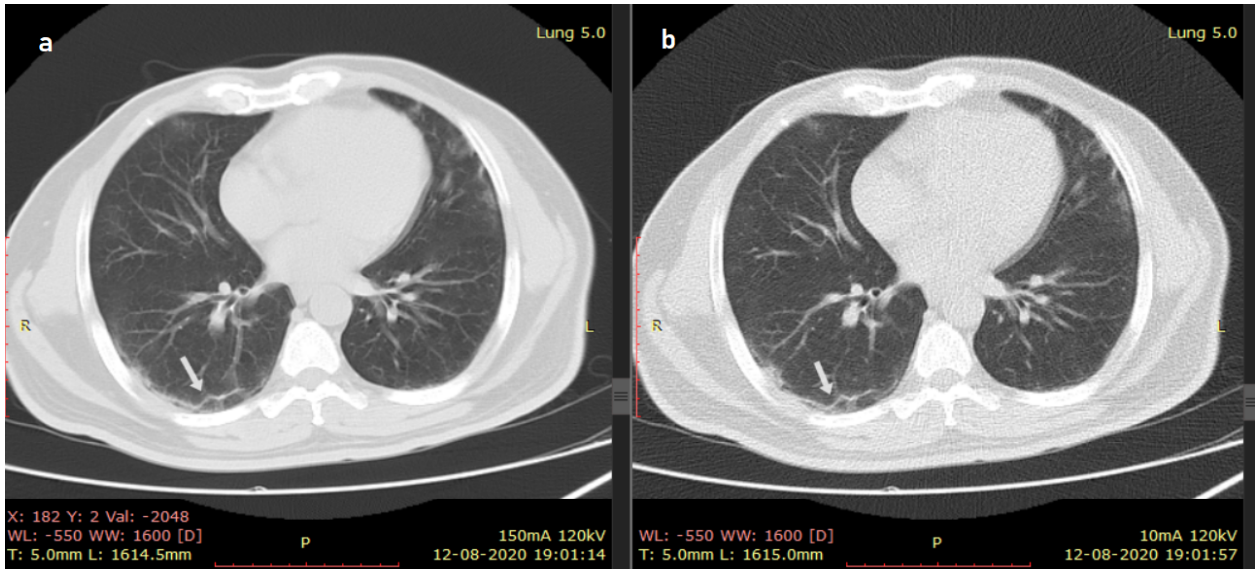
Chest CT Depiction of Peripheral Ground Glass Opacities and Subpleural Bands in COVID-19 Pneumonia Patient
